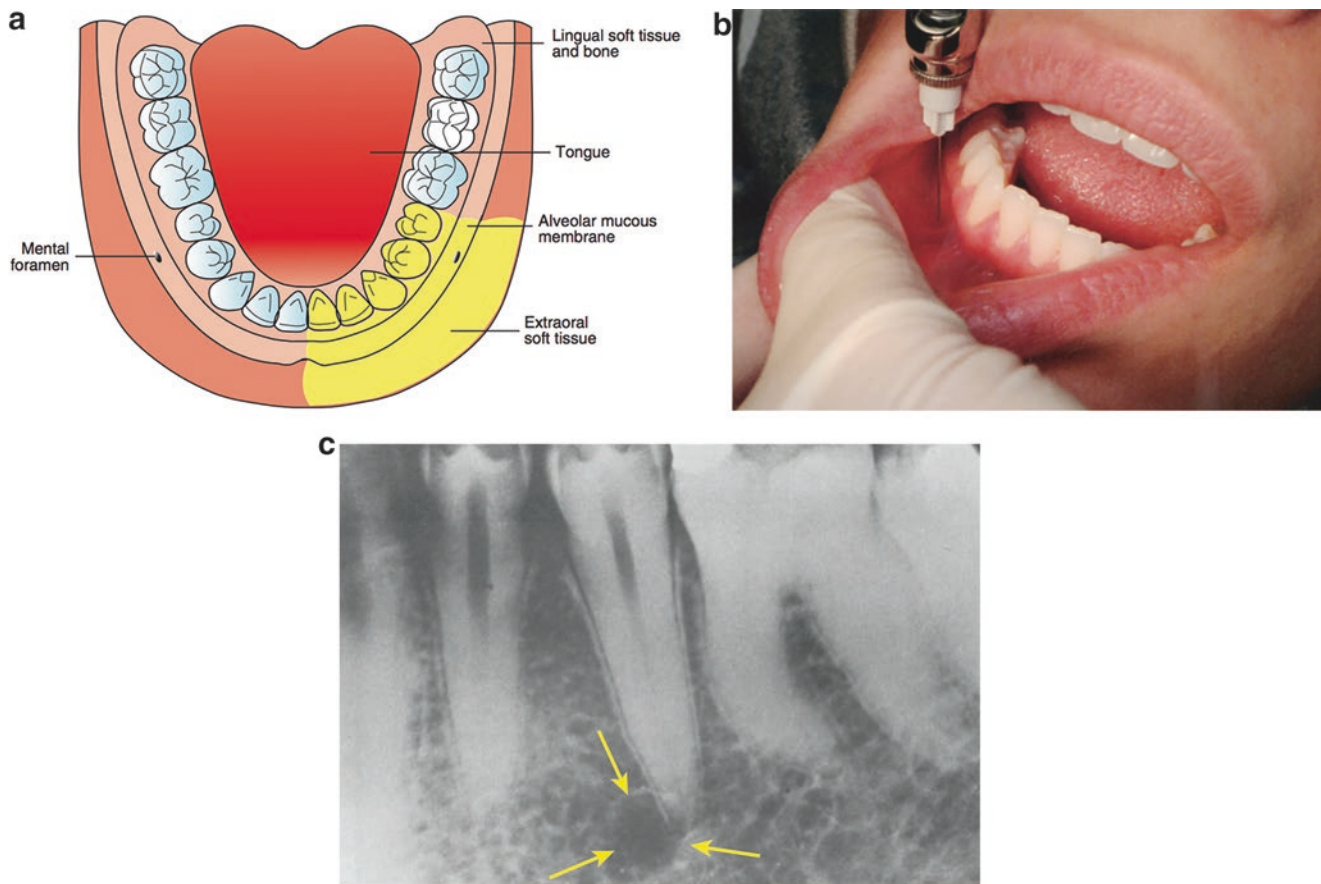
Incisive (mental) nerve block ((a) area anesthetized; (b) technique; (c) radiographs can aid in locating mental foramen)
